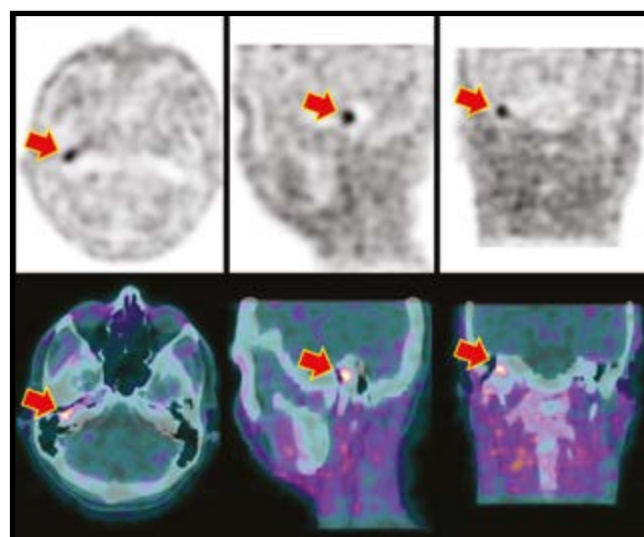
PET (upper row) and PET/CT images (lower row) showing a focal area of increased F-18-DOPA uptake in the right middle ear (arrow).
